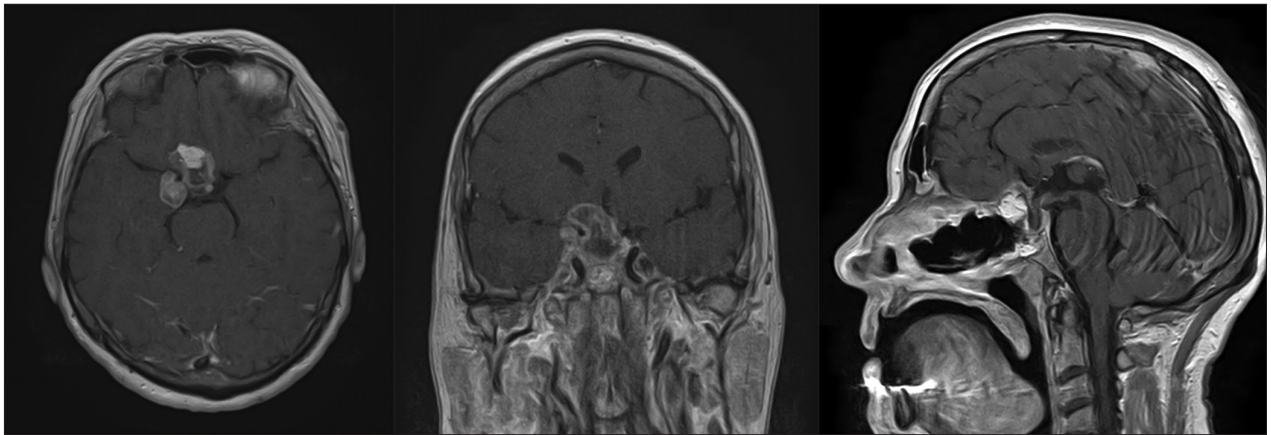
April 2021. Non-enhanced axial, coronal, and sagittal T1-weighted MRI showing residual elements of pituitary adenoma in the right cavernous sinus three months after surgery
